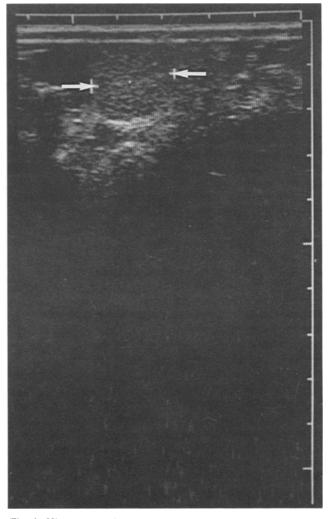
Ultrasonographic patterns (arrows) of insulinoma: hyperechogenic mass of pancreatic head.
